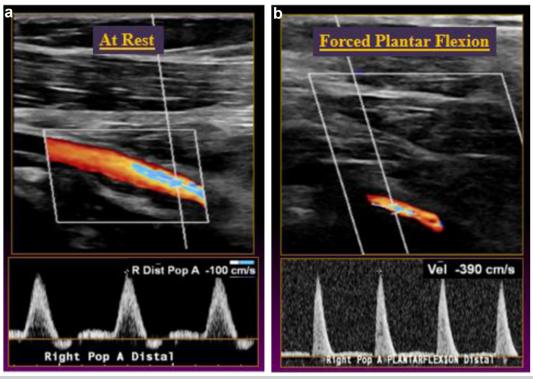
Right leg preoperative duplex ultrasound examination. (A) At rest. (B) Active plantarflexion.
